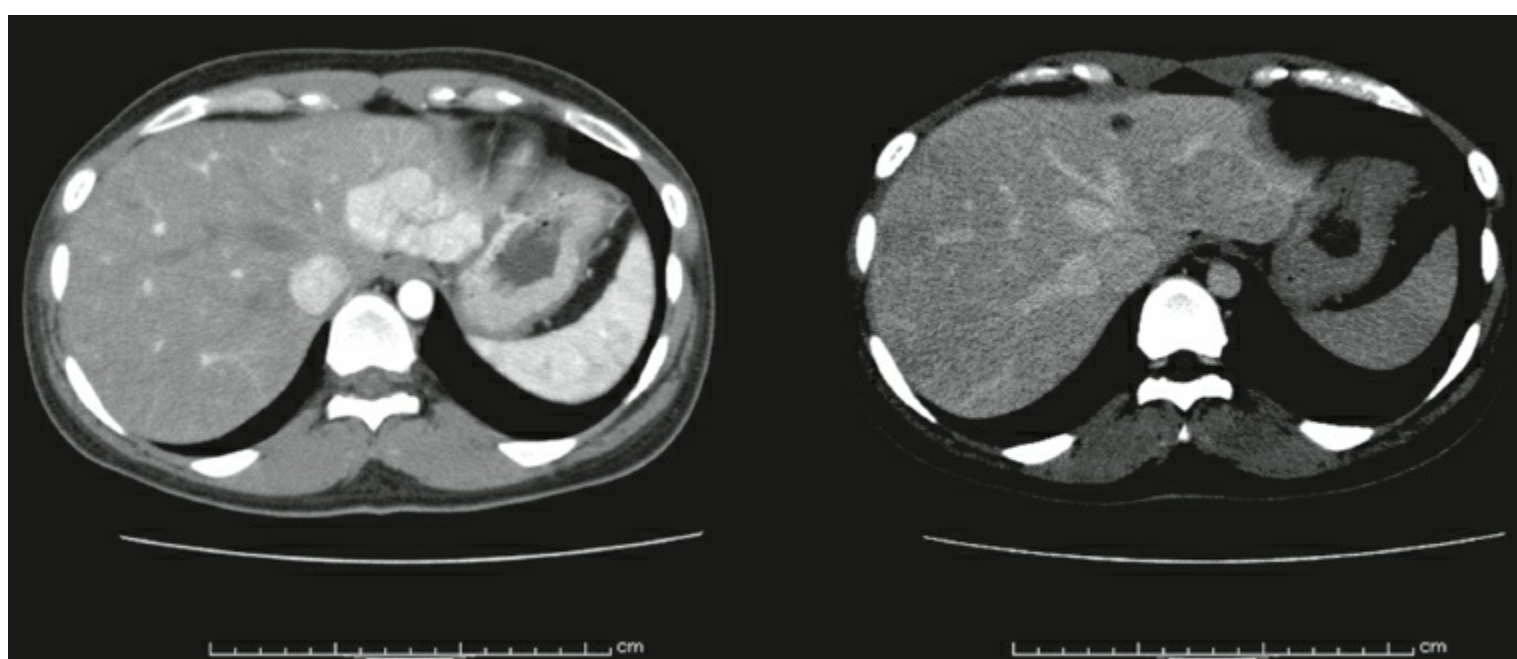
Typical dynamic CT image of focal nodular hyperplasia. The lesion is homogeneously enhanced in the arterial phase with central hypodensity area suggestive of a central scar (left). The mass becomes isodense in the portal phase (right).
